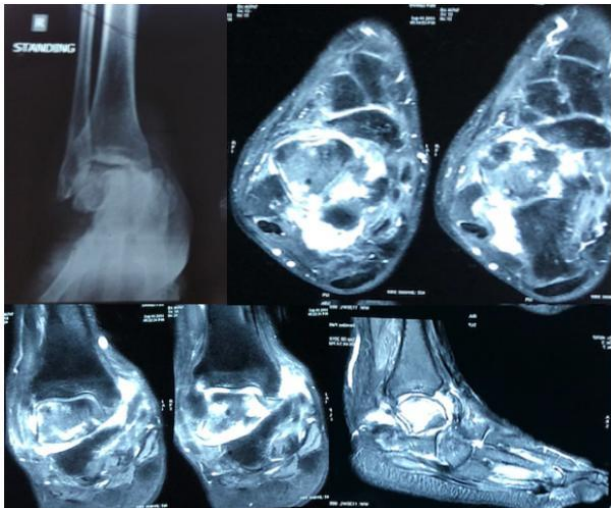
Preoperative X-ray and MRI showing subluxated talonavicular and talocalcaneal joint with ankle and inter tarsal inflammatory arthritis with marrow oedema of talus.
